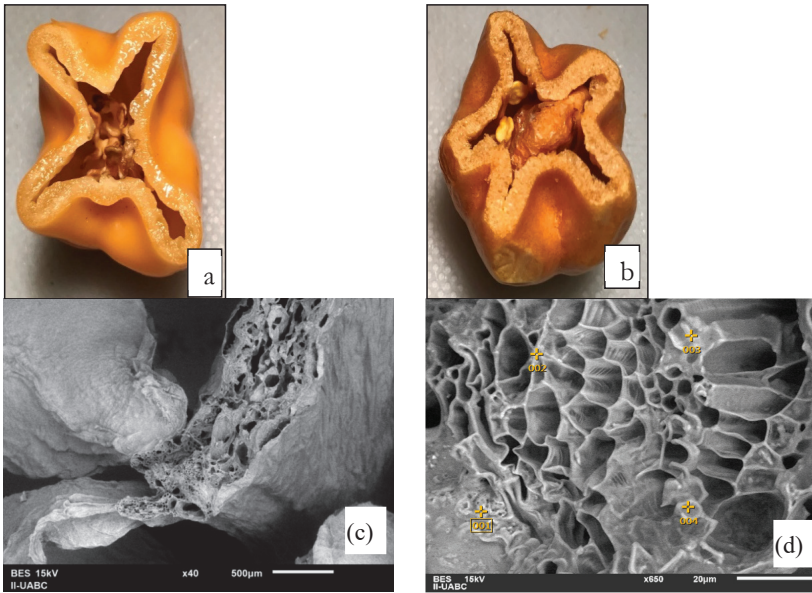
Images of fresh and freeze-dried habanero pepper: (a) before freeze-drying, (b) after freeze-drying, (c) SEM image of dried sample at 40 \times , (d) the place where energy-dispersive X-ray analyses (EDX) were performed (650 \times) for a dried sample.
